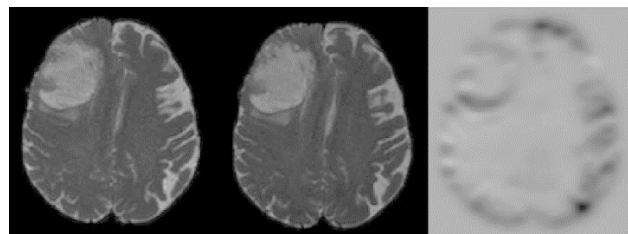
The generation of a field map based on the method using two DWI $b = 0$ images acquired with both phase encoding polarities. On the left: the AP DWI $b = 0$ image, in the middle: the PA DWI $b = 0$ image, on the right: a created field map.
